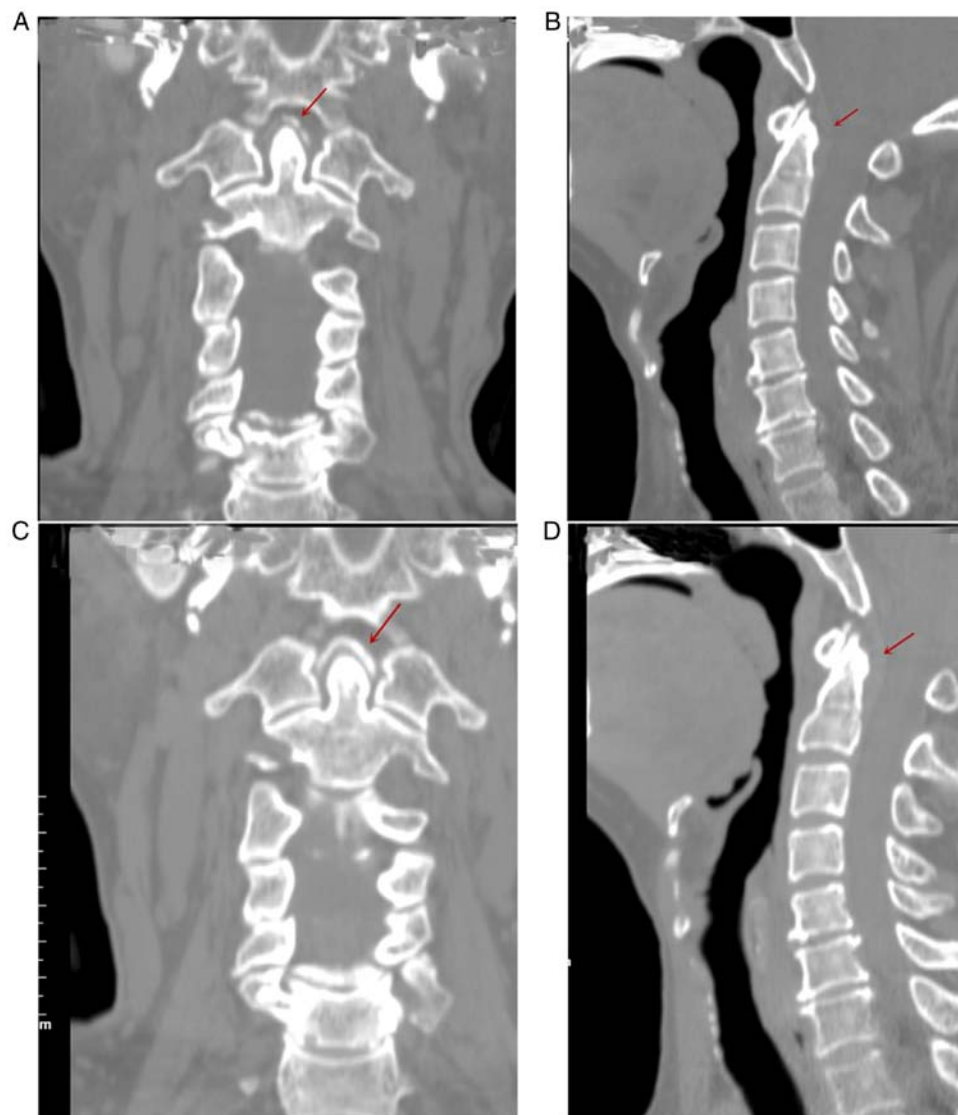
CT scans of a 73-year-old female. (A and B) CT scans at baseline revealed (A) an arc-shaped calcification of the apical ligament in the anterior area of the odontoid process and (B) vertical line-like calcification of the cruciate ligament in the posterior area of the odontoid process. (C and D) Follow-up CT images at 3 months displayed the (C) arc-shaped calcification of the apical ligament in the anterior area of the odontoid process and (D) vertical line-like calcification of the cruciate ligament in the posterior area of the odontoid process. Red arrows indicate the sites of calcium deposition.
